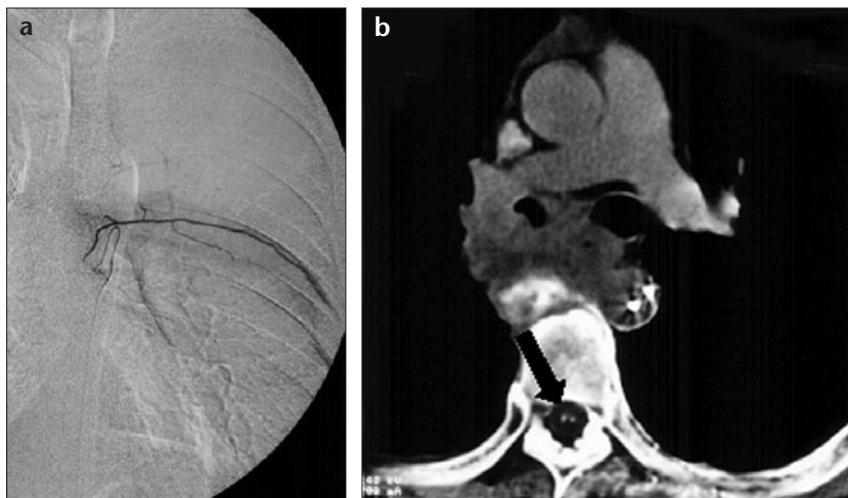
a, b. Patient no 26. Angiogram via the left sixth intercostal artery (a) shows enhancement of part of the tumor. Neither spinal nor esophageal branches can be seen on angiography. Selective CT angiogram via the left sixth intercostal artery (b) shows spinal cord enhancement (*black arrow*).
